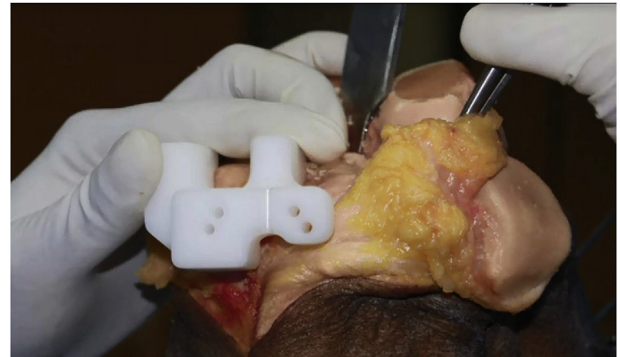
The computed tomography based 3D printed jigs used for total knee arthroplasty. The left is the femoral jig matching the anterior distal femoral anatomy and the tibial jigs on the right side matches the proximal anterior tibial anatomy.
